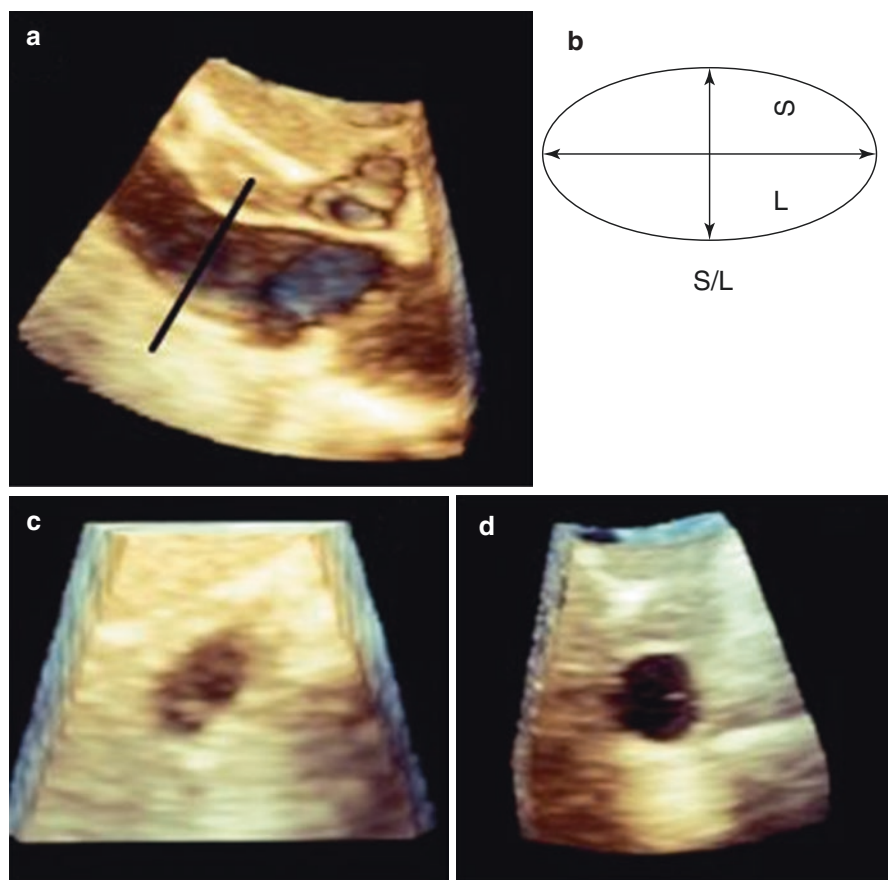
Estimation of the right atrial pressure using cross-sectional imaging of the inferior vena cava. A cross-sectional cut of the inferior vena cava is rendered using 3D echocardiography dataset obtained from the subcostal view (panel a). The ratio of the short (S) to long (L) diameter can then be determined (panel b). Patients with normal right atrial pressure (<10 mmHg) typically have an ovoid shape of the inferior vena cava ($S/L < 0.69$) (panel c) while patients with elevated right atrial pressure have a round shape (panel d)
